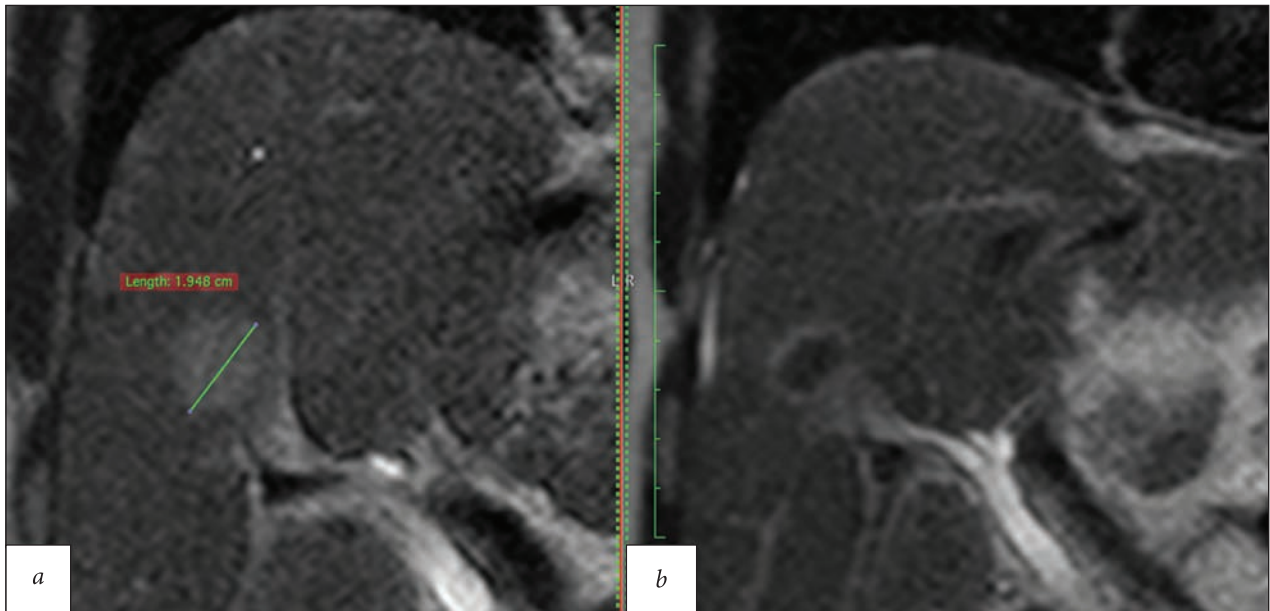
MRI of the hepatobiliary system before treatment (a) and 4 months after the RFA procedure (b) in segment 5 of the liver
